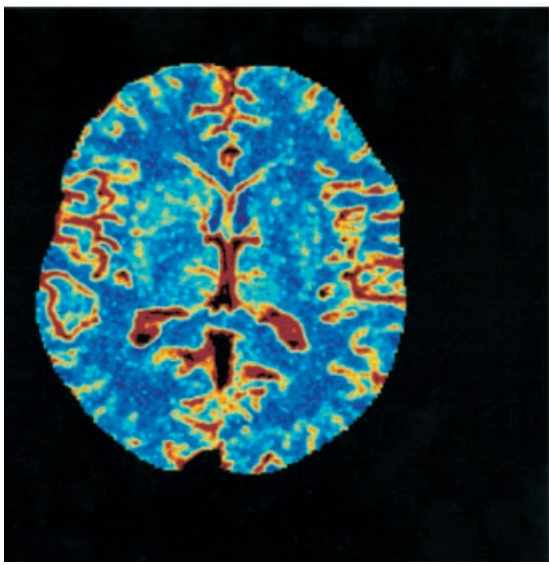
This rCBV map (cubic centimeters per 100 g) is inferred from a quantitative assessment of the partial-volume averaging in each pixel. Contrast enhancement involves only the vascular volume indeed. As seen in Fig. 3, time–concentration curves measured in vivo during perfusion CT studies are thus more marked in pure vascular pixels than in pixels including blood within capillaries but also neurons, axonal tubes, and myelin sheaths, where the vascular volume represents only a few percent of the total tissue volume, thus leading to a partial-volume averaging effect. This partial-volume effect can be exploited to determine information about the fraction of vascular volume within the total tissue volume and to infer an rCBV map. Calculation of rCBV map necessitates knowledge of the contrast enhancement profile in a reference pixel devoid of partial-averaging effect. This pixel is usually chosen at the center of the superior sagittal venous sinus
